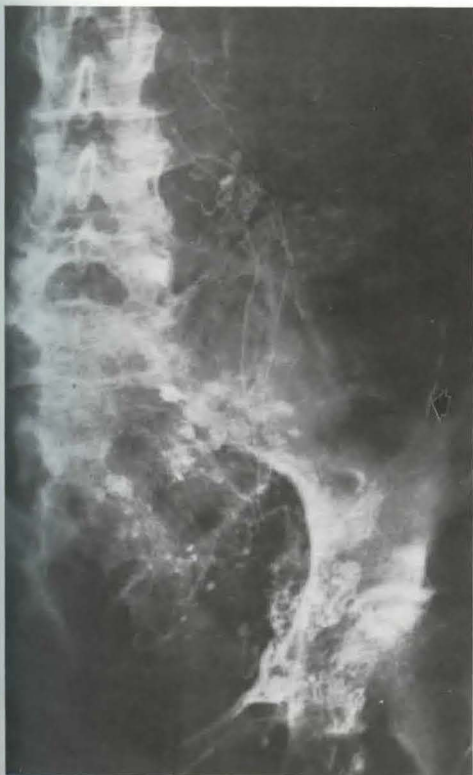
Malignant lymphoma: opacification of the sigmoid wall (arrow) in relation with left iliac adenopathies diagnosed by ultrasound
